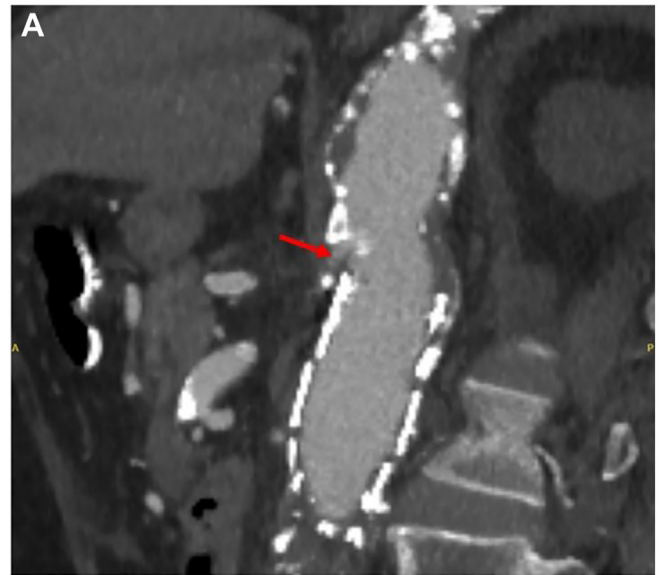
(A) Preoperative views demonstrating patent superior mesenteric artery (red arrow). (B) Postoperative sagittal view of computed tomography (CT) scan demonstrating occlusion of the superior mesenteric artery (red arrow).
